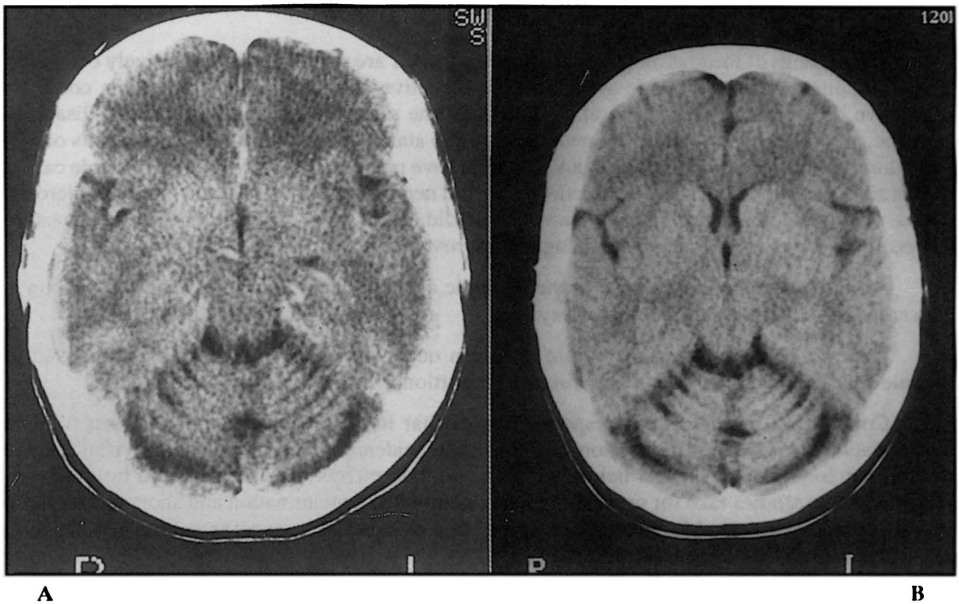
CT shows only marked pancerebellar atrophy (A). Control CT two years later remains unchanged (B).
